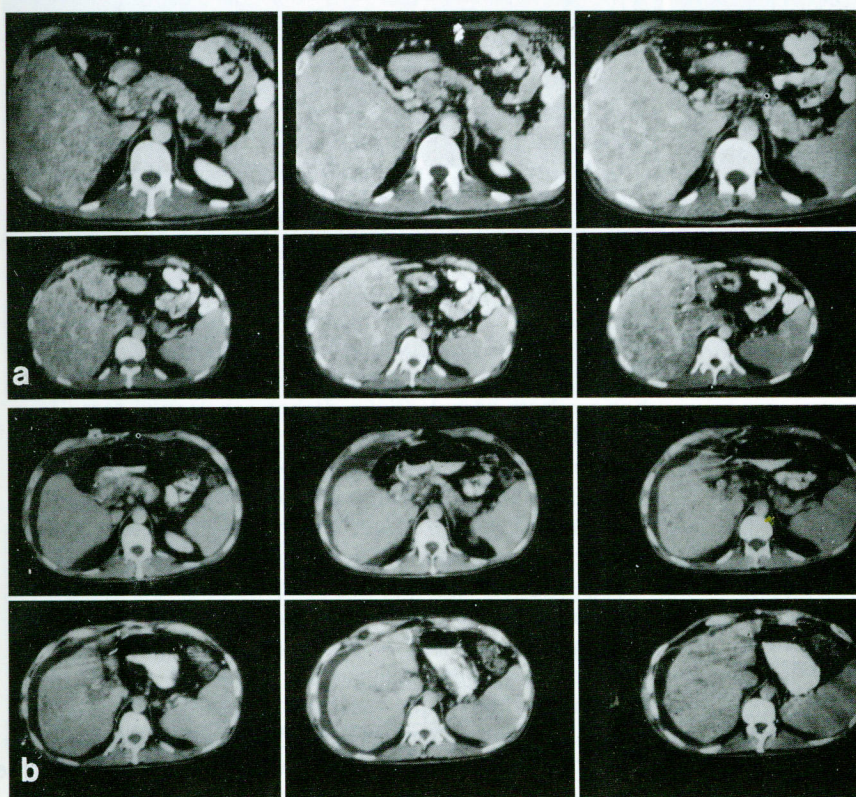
a CT-scan of locally infiltrating carcinoma of the head of pancreas with disseminated liver metastases. b CT-scan of same patient 12 months after regional chemotherapy
